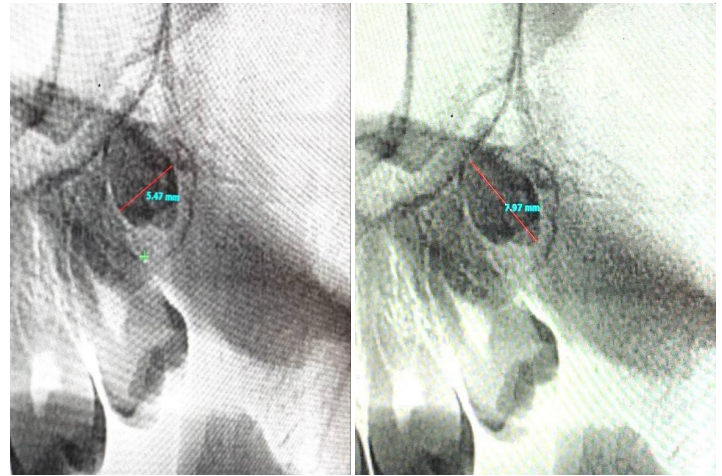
Orthopantomogram (OPG) showing the dimensions.
